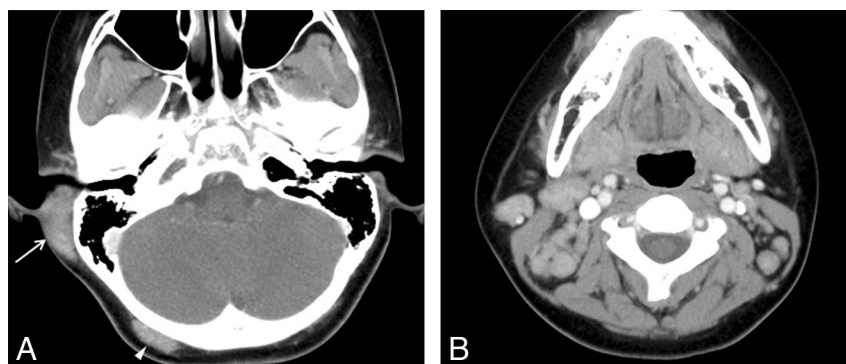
KD involving the postauricular area and occipital scalp in an 11-year-old boy. *A*, Postcontrast axial CT scan shows an ill-defined soft-tissue mass with homogeneous moderate enhancement involving the postauricular area on the right (arrow). Also note a smaller mass with the similar imaging characteristics on the right occipital scalp (arrowhead). *B*, Postcontrast axial CT scan shows multiple moderately enhancing and enlarged lymph nodes, right greater than left, on both sides of the neck.
